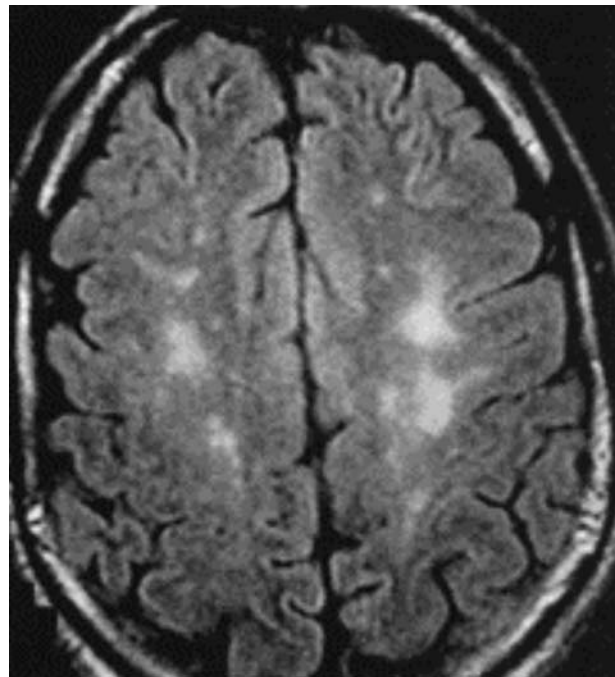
MRI of the brain showing fat emboli
